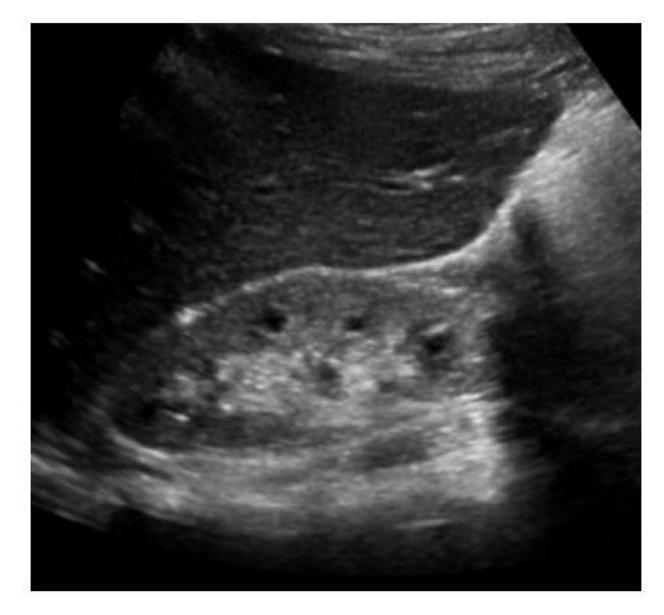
Renal ultrasound in NPHP
